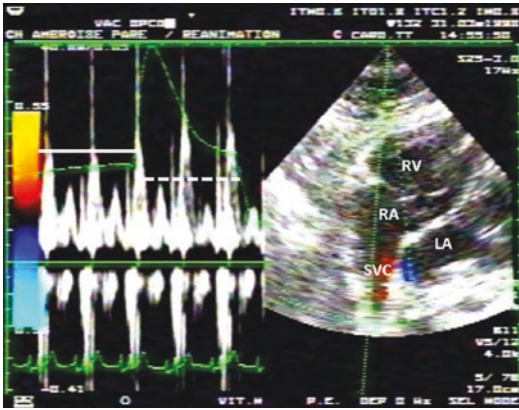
Transthoracic echocardiography by a subcostal approach in a ventilated patient. The pulsed wave Doppler sample is placed at the entry of the superior vena cava (SVC) in the right atrium (RA). It shows a decrease in maximal velocity of the flow into the SVC during tidal ventilation (full white line) compared to expiration (dotted white line). The airway pressure trace is in green on the screen. RV right ventricle, LA left atrium
